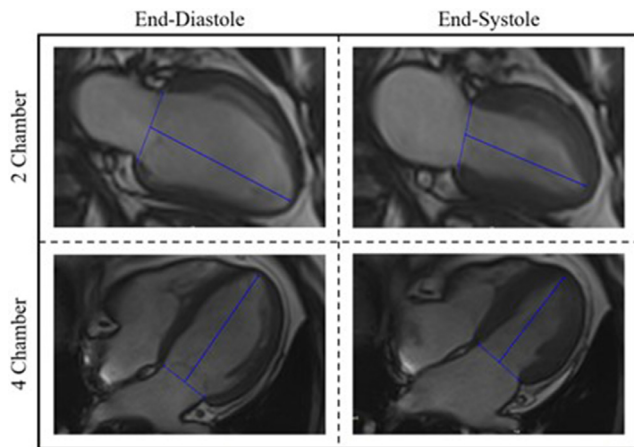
shows cardiovascular magnetic resonance images in a 2-chamber and 4-chamber view at end-diastole and end-systole. The long-axis shortening technique calculates shortening of the ventricle (mitral valve to apex) across the cardiac cycle.
